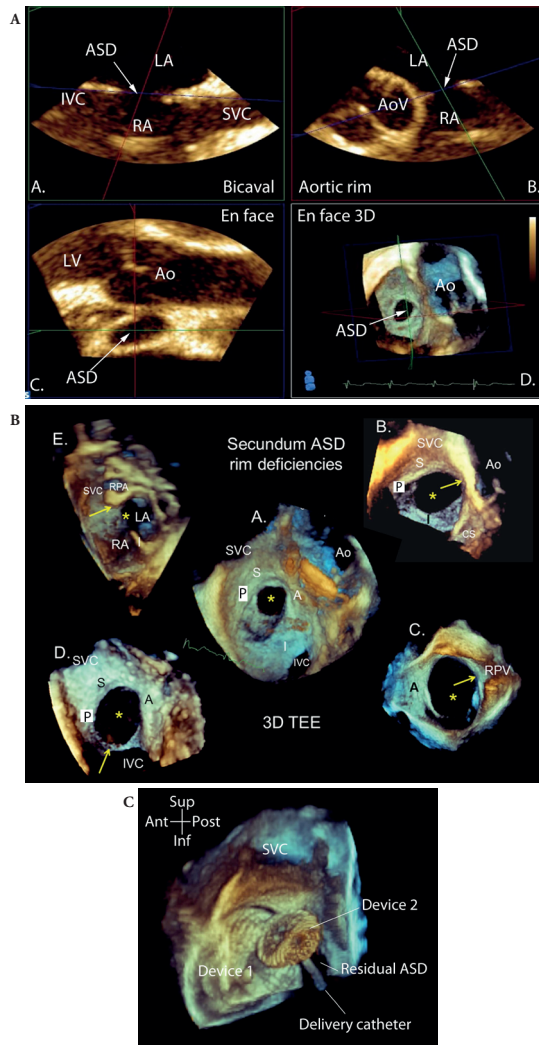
(A) 3D transoesophageal projection of MPR images of a secundum atrial septal defect. The blue plane is orientated to include the margins of the defect (*A* and *B*) which defines the en face projection shown in cross-section in (*C*) and rendered view in (*D*). The rims of the defect can be measured either on the MPR images or rendered image. (B). Transoesophageal 3DE rendered images of the morphology, size and rims of the atrial septal defect (*) of atrial septal defects with deficient rims in different regions. The zones where there is a deficient rim are marked with an arrow. The rims appear adequate throughout (*A*), deficient aortic rim (*B*), deficient right pulmonary vein rim (*C*), deficient inferior vena caval rim (*D*) and superior vena caval rim (*E*). Images (*A*), (*B*), and (*D*) are viewed from the right atrial side and Image (*C*) from the left atrial side. Image (*E*) cuts through the atrial septum so that the crest of the septum and the superior position of the defect can be visualised. (C). Transoesophageal real-time 3DE image of deployment of a second septal occluder to close a residual atrial septal defect. This 3D rendered projection from the left atrial aspect shows the relative position of the two septal occluders, the residual defect and the delivery catheter. SVC, superior vena cava; IVC, inferior vena cava; LA, left atrium; RA, right atrium; Ao, aorta; RPV, right upper pulmonary vein; S, superior; P, posterior; A, anterior; I, inferior; LV, left ventricle; ASD, atrial septal defect; AoV, aortic valve; MPR, multiplanar reformatted.
